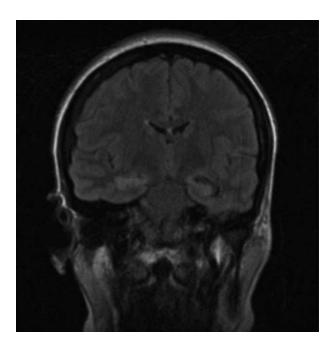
Coronal T2 fluid-attenuated inversion recovery images on MRI of brain revealing dominant hyperintensity in bilateral hippocampi.
